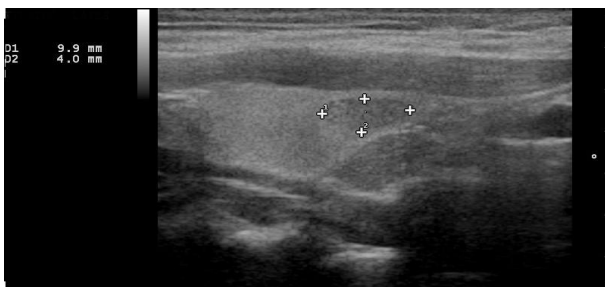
Right longitudinal B-mode ultrasound image of the neck. A hypoechoic heterogeneous and well-demarcated lesion with punctate echogenic foci is seen at the right thyroid inferior pole, measuring 9.9x4.0mm.
